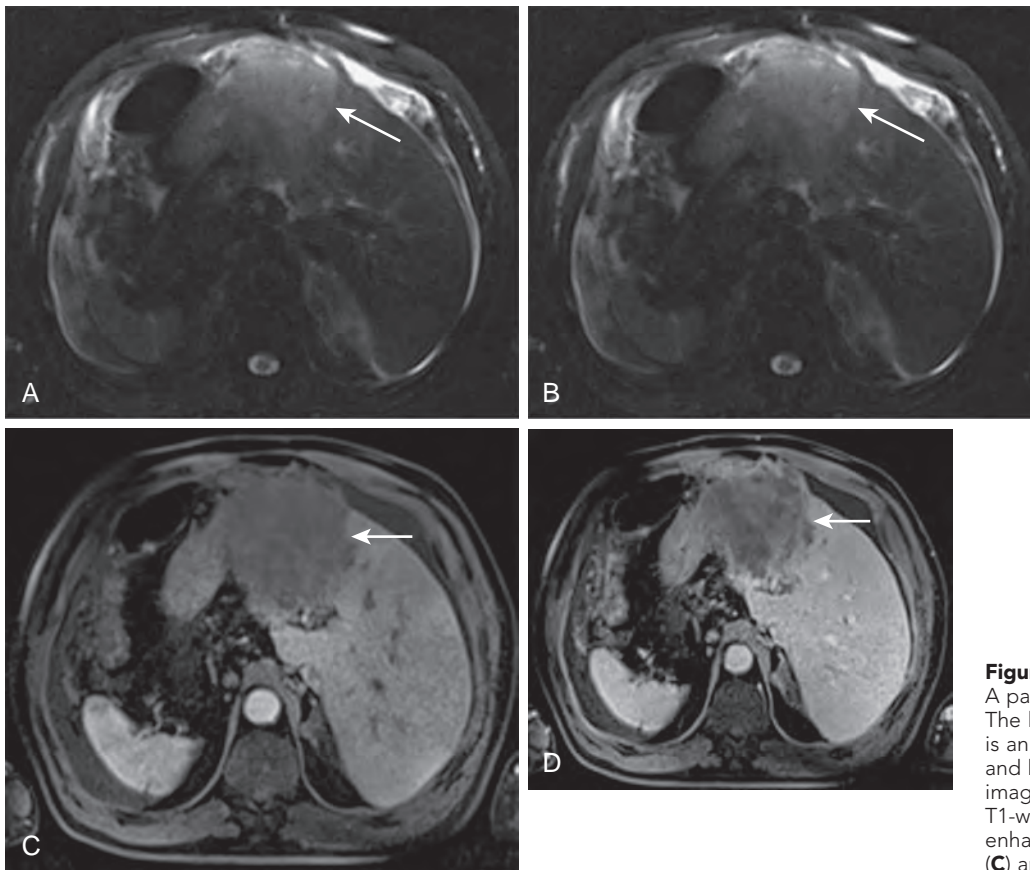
ICAC: MRI findings. A patient with situs inversus (arrows). The lesion is in the "left" liver lobe and is an ICAC. It is poorly demarcated and hyperintense on the T2-weighted image (A). ICAC is hypointense on the T1-weighted image (B) and shows late enhancement as depicted on the arterial (C) and late phase (D) images.
